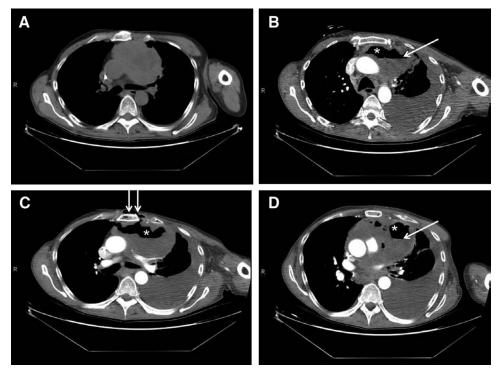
(*A*) Bulky mediastinal mass on CT scan, without contrast, before sunitinib; (*B–D*) mediastinal mass containing air (asterisk), air-fluid levels (arrow), with dissection in the anterior chest wall and subcutaneous air (double arrow), and large left pleural effusion after 3 weeks of sunitinib. CT, computed tomography.
